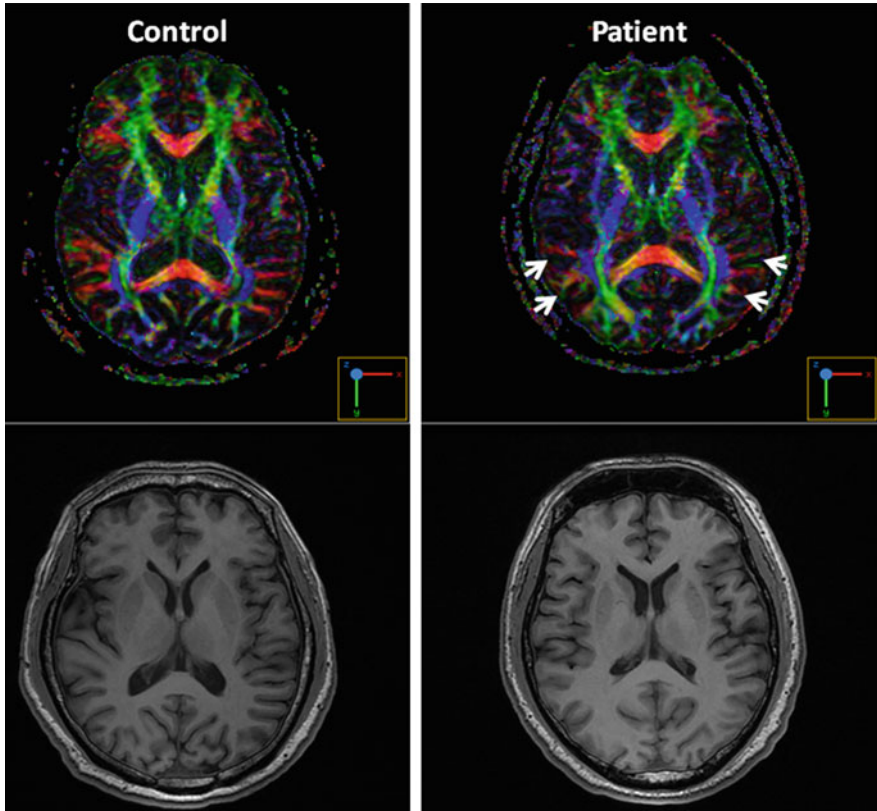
Early cerebral microstructural changes related to vitamin B12 deficiency. Example of a 50-year-old, 10-year-education level, male patient with subtle cognitive complaints. His performance in Cognitive Abilities Screening Instrument was normal (93/100). Notice the loss of directionality within various association fibers on color-coded diffusion tensor images (*arrows*) compared with age-matched healthy control (*upper row*: repetition time = 8325; echo time = 83; diffusion weighting factor $b = 1000$ sec/mm², plus one $b = 0$ image). In conventional MRI, his brain parenchyma is visually regarded to be normal in size (*lower row*: 3D fast-spoiled gradient; repetition time = 8; echo time = 3)
